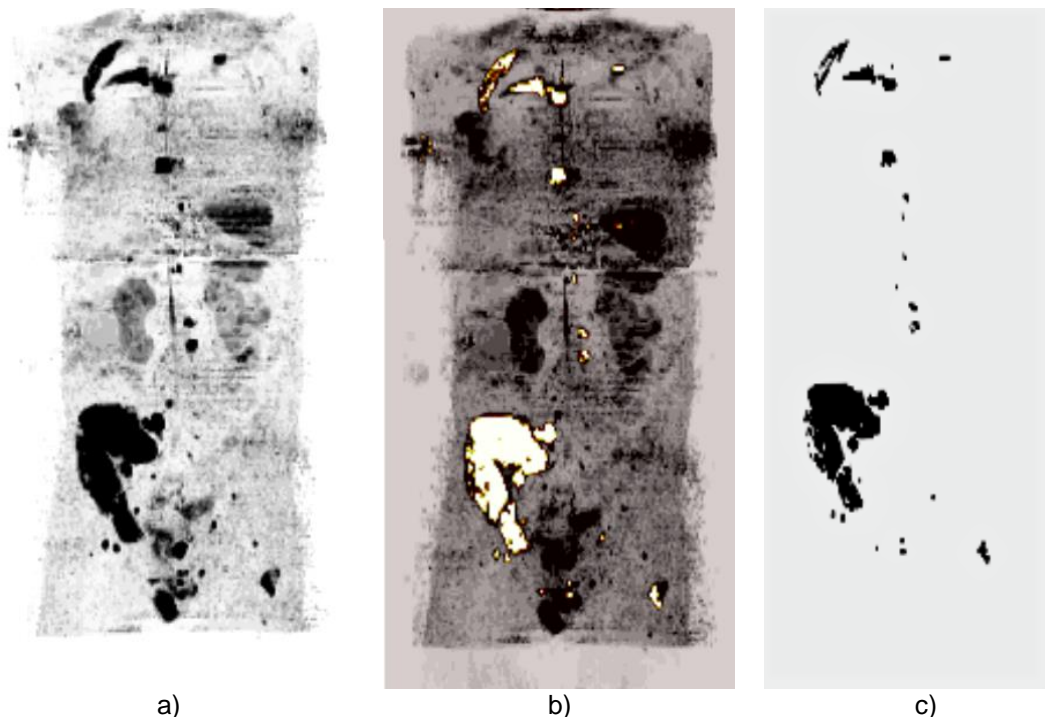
Whole-body DW-MRI VOI Segmentation: Study Patient FAP03 Baseline Scan. (^{99m}Tc Bone Scan showing sites of prostate cancer bone metastases and ¹⁸F-Fluoride PET scan showing uptake at sites of bone metastases can be reviewed in whole-body ¹⁸F-Fluoride methodology) a) extrapolated high b-value (1400s/mm²) image of same patient b) high-b value image with segmented pathological bone signal mask overlaid c) pathological bone signal mask which will be applied to ADC map for whole-body quantification)
